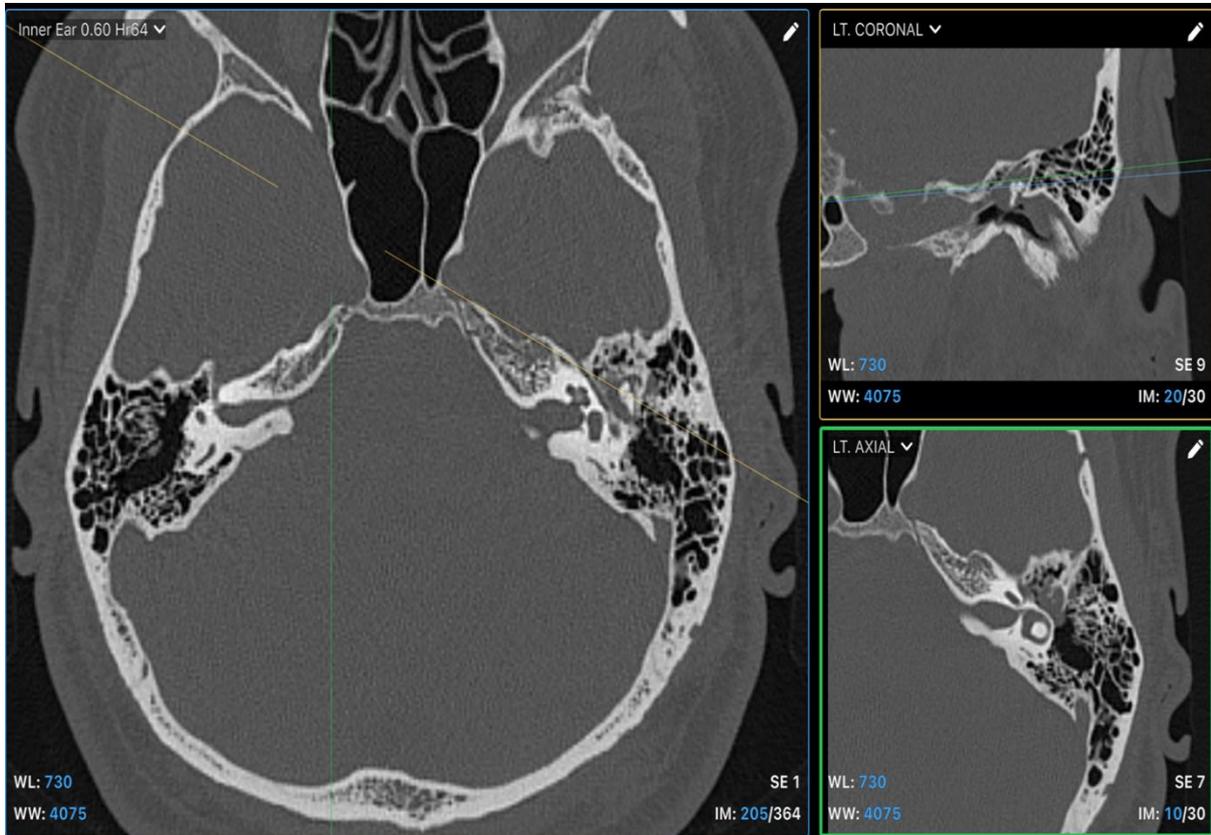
Computed tomography scan of temporal bones without enhancement. A soft-tissue density mass is seen filling the left middle ear, epitympanum and tympanic antrum.
